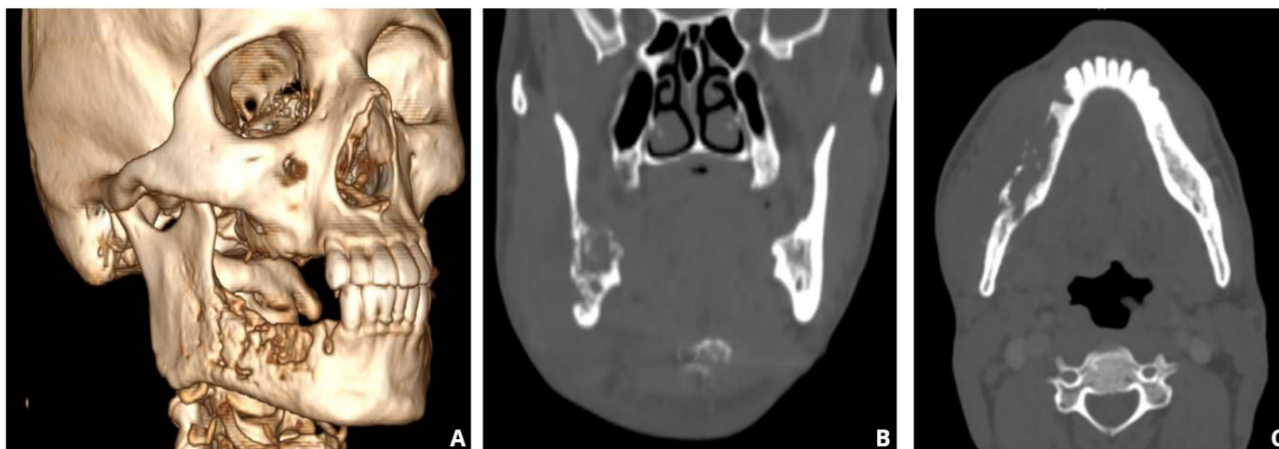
CT scan showing an aggressive osteolytic lesion of the right mandible with cortical bone destruction on 3D reconstruction (A), coronal view (B) and axial view (C)
